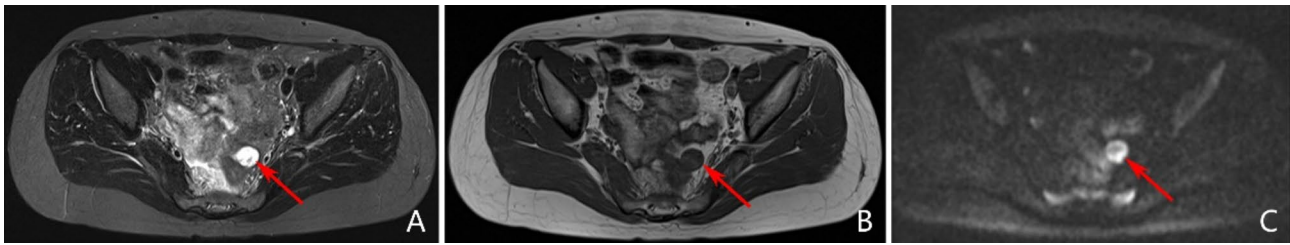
Patient 10, underwent resection of a primary left adnexal lesion 5 years prior and was found to have a rectal fossa mass (red arrow), clinically and pathologically confirmed as AGCT-NEL, FIGO stage IIIA. (A) Axial T₂WI-FS: A multilocular cystic mass in the rectal fossa displays high signal intensity on T₂WI, with visible septations and relatively clear boundaries. (B) Axial T₁WI: The mass appears isointense, with relatively clear margins. (C) DWI: The mass shows significantly uneven high signal intensity
